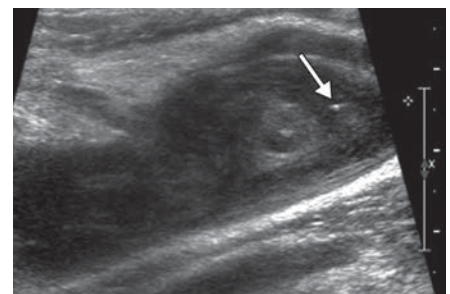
58-year-old man with infected fluid collection due to septic arthritis and Baker cyst after recent knee arthroscopy. Gray-scale ultrasound image of popliteal fossa shows complex cystic mass with hyperechoic foci suggestive of gas bubbles (arrow). No calcified bodies were seen at radiography (not shown). Complexity and presence of air suggest infection.
